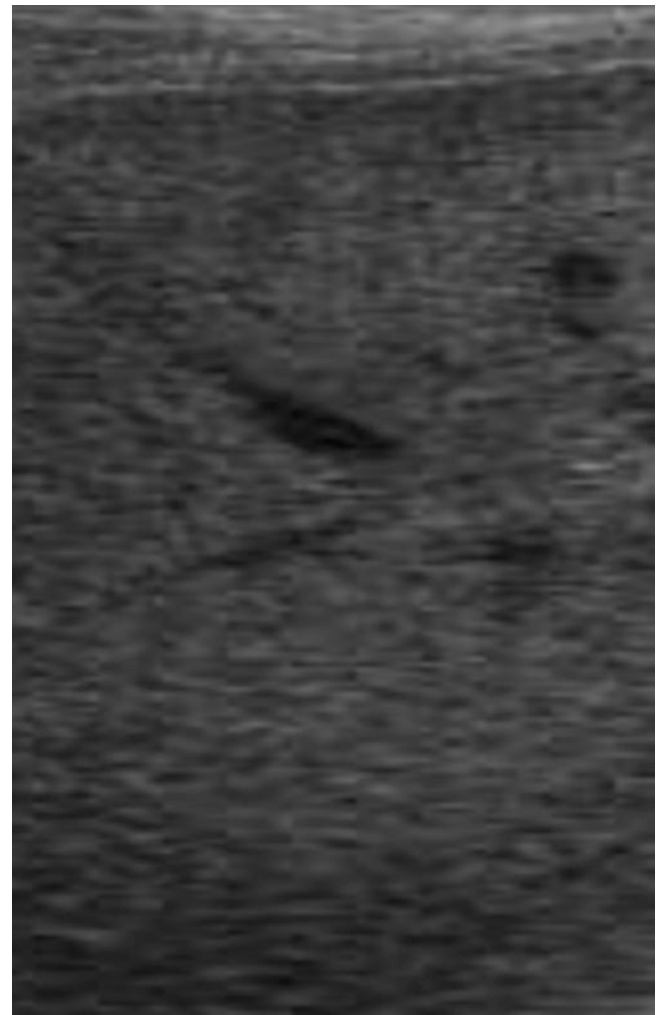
Ultrasonography aspect of fatty liver disease, showing a hyperechoic parenchyma with posterior attenuation
